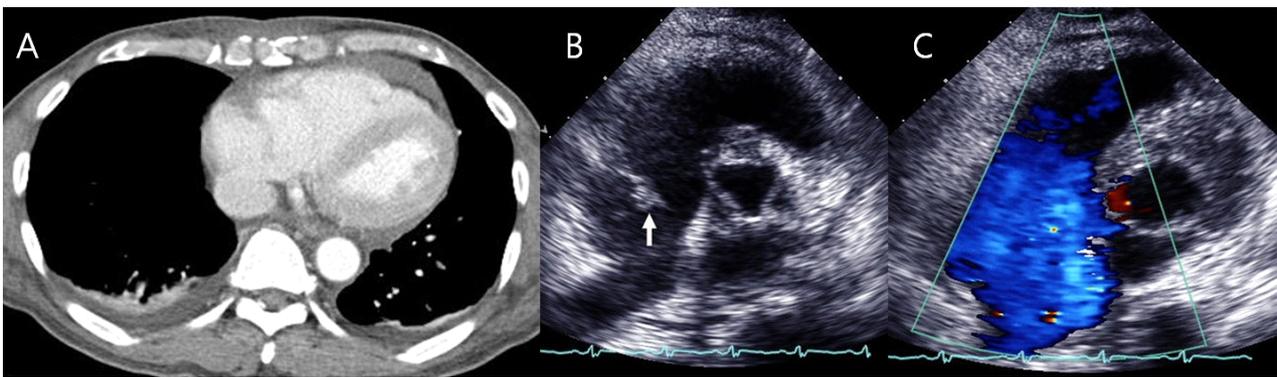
Chest computed tomography scan showed small amounts of pericardial effusion anterior to the right ventricle and right pleural effusion(A). Echocardiography showed that the tricuspid valve anterior leaflet had flailed papillary muscle (arrow)(B). Doppler echocardiography showed severe regurgitant flow at the right atrioventricular level during systole(C).
